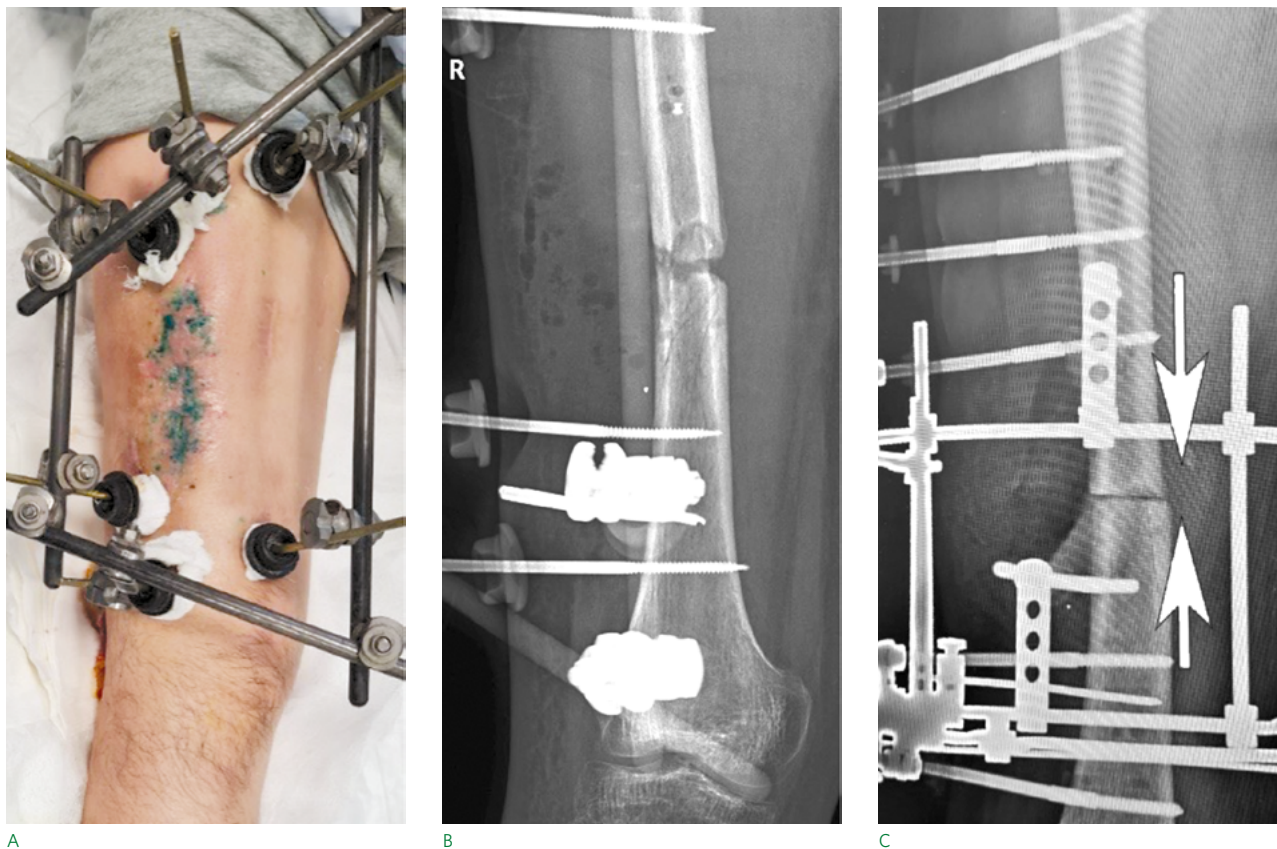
Wounded man with a gunshot fracture in the middle third of the femur. Appearance and radiographs 6 months after injury: A — appearance of the limb fixed with a MTRK; B — radiograph of the femur, there is an unrecoverable diastasis of 7 mm between the fractures, which excludes consolidation; C — radiograph of the hip fixed with IA after resection of the fracture edges and creation of axial compression
